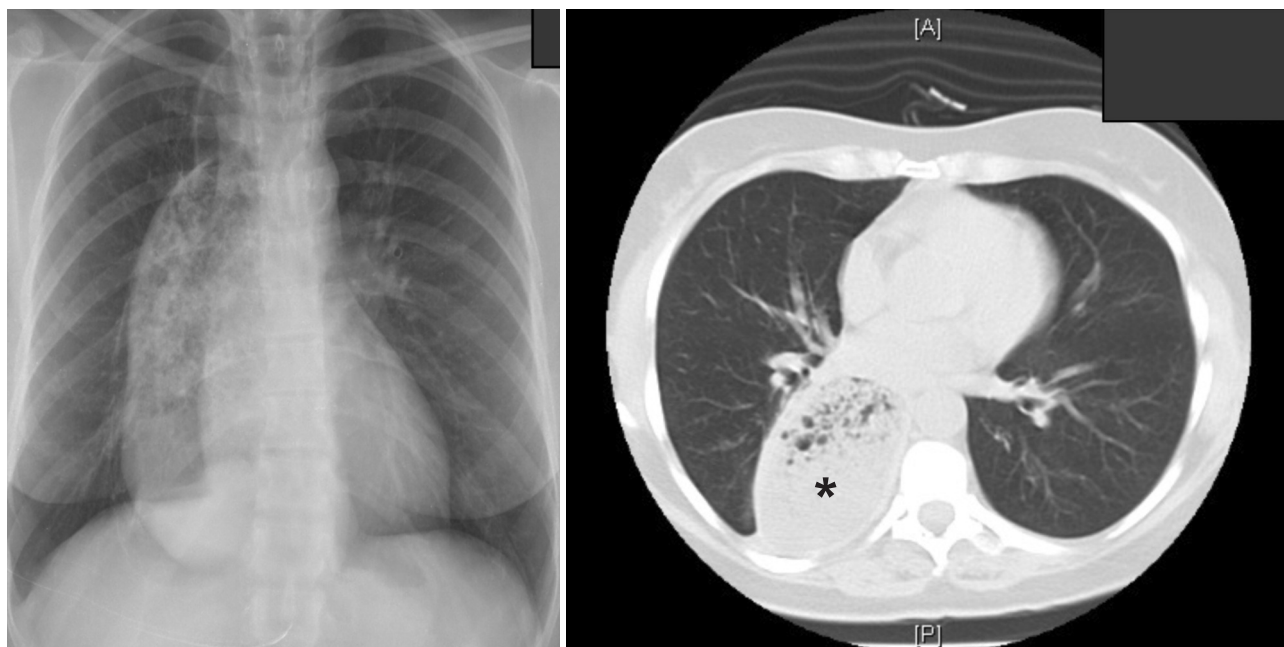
Left: X-ray showing well-defined mediastinal widening. Right: CT scan showing marked esophageal dilatation and elongation with abundant food content (asterisk).
